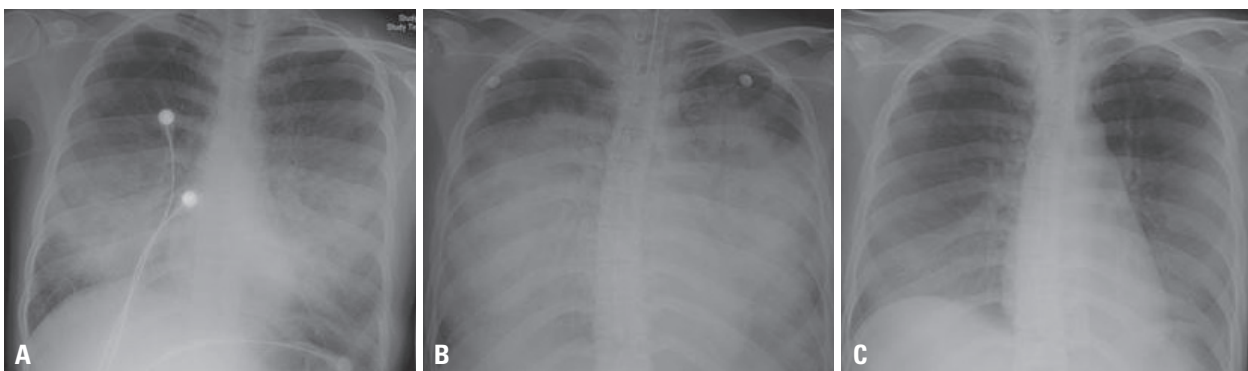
Chest X-ray features of the patient: (A) when the symptoms presented, (B) immediately after intubation, (C) before discharge from the intensive care unit.
